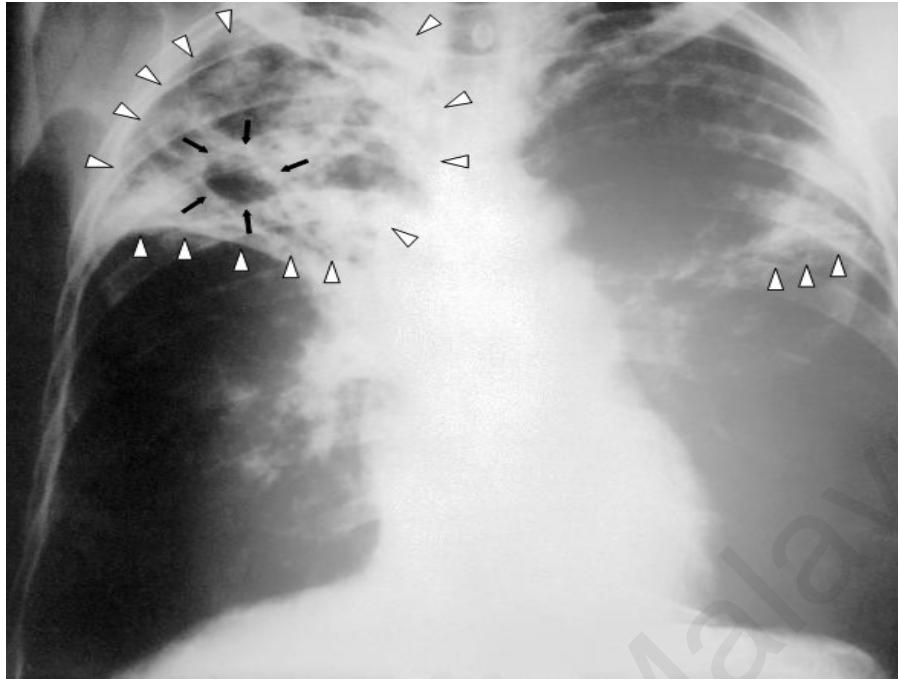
An x-ray image portraying tuberculosis (Adapted from Müller (2016), CC BY 3.0)
